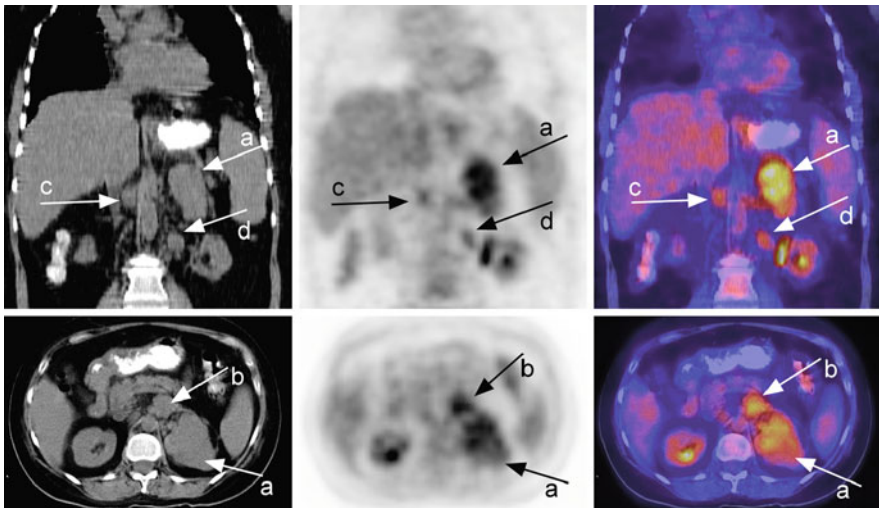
A 51-year-old woman presenting with Cushing's syndrome and large, multilobulated left adrenal mass. Staging [^{18}F]-FDG-PET-CT scan reveals intense and heterogenous FDG activity in 8.2 cm left adrenal mass (a) consistent with ACC and retroperitoneal metastatic lymphadenopathy in one aortocaval (c) and two left para-aortic lymph nodes (b, d) (Reprinted with permission from [35])
